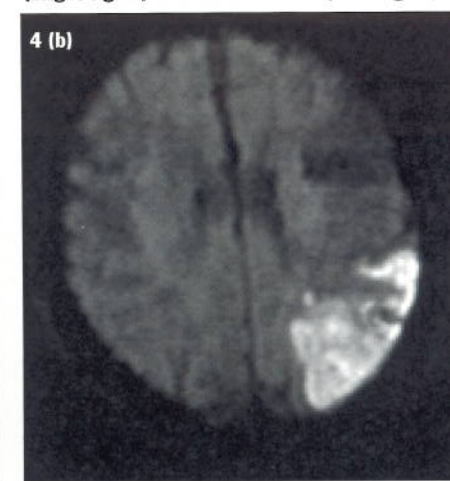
Comparison of a conventional T2-weighted MRI (a) with a Diffusion Image (b) demonstrates the keen ability of Diffusion Imaging to differentiate between acute stroke (bright signal) and chronic stroke (dark signal).
